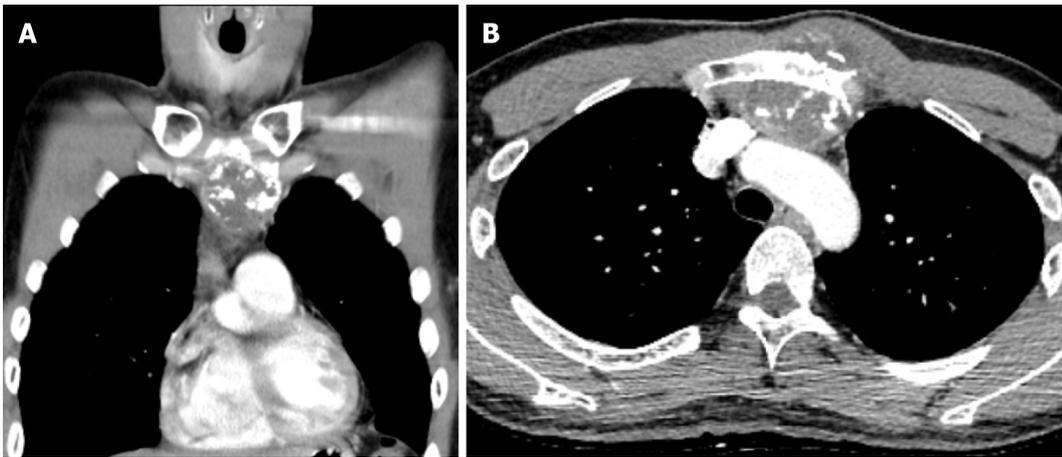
Focal osteoblastic mass in the sternum with bony exostosis and adjacent soft tissue calcification. A and B: Coronal (A) and axial (B) views of contrast computed tomography.
